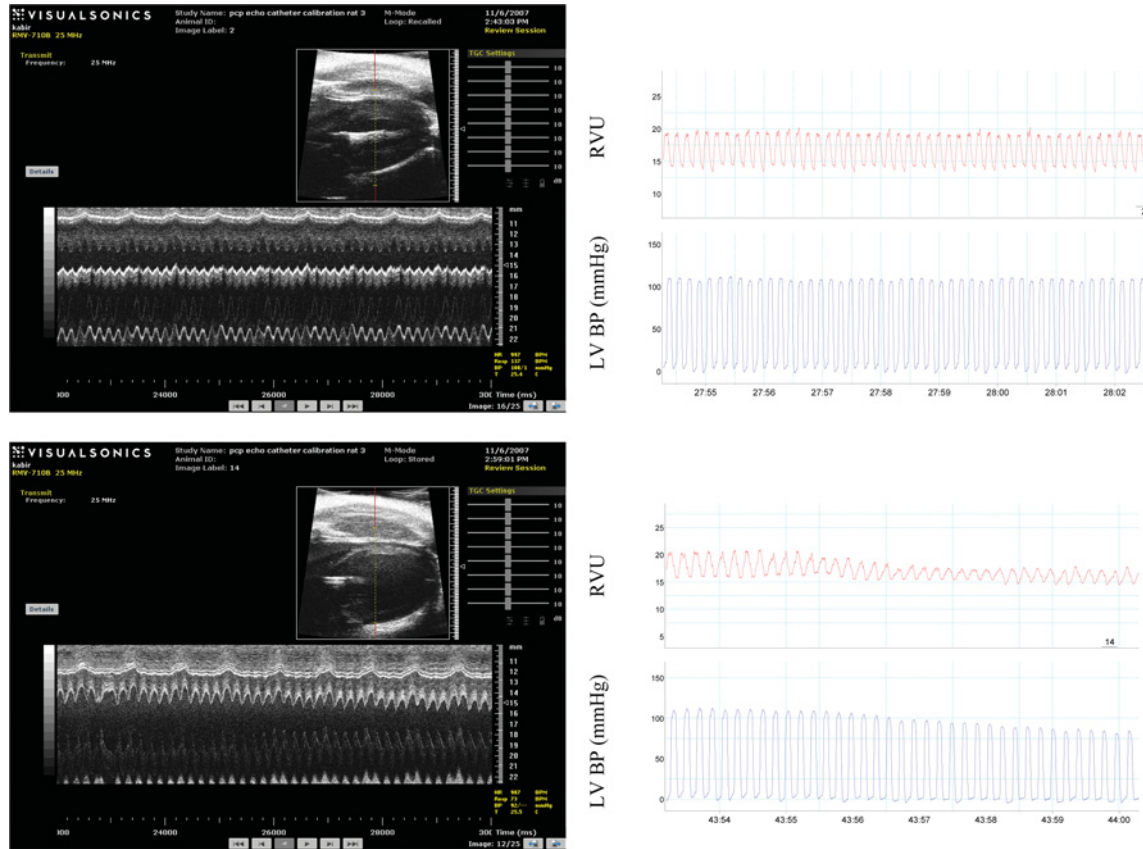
Simultaneous acquisition of LV volume measurements by echocardiography and by micro-tip pressure-volume catheter transducer
